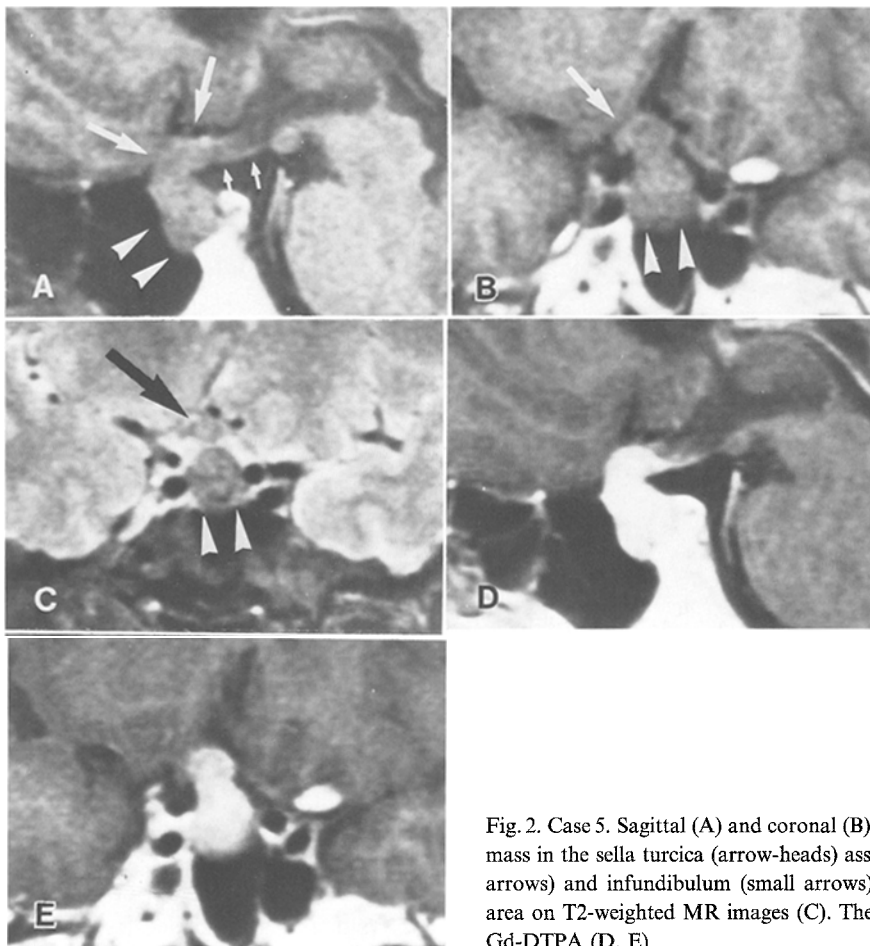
Case 5. Sagittal (A) and coronal (B) T1-weighted MR images reveal an iso-intense mass in the sella turcica (arrow-heads) associated with a thickened pituitary stalk (large arrows) and infundibulum (small arrows). These findings appeared as a low-intensity area on T2-weighted MR images (C). These lesions were homogeneously enhanced with Gd-DTPA (D, E)
